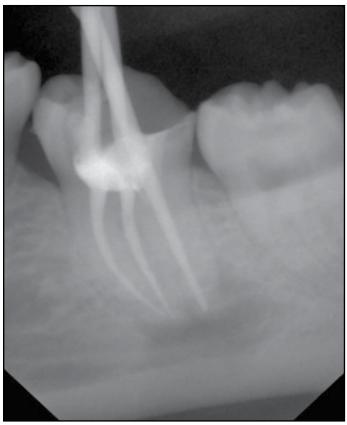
Pre-surgical radiographic view of affected tooth 36.
